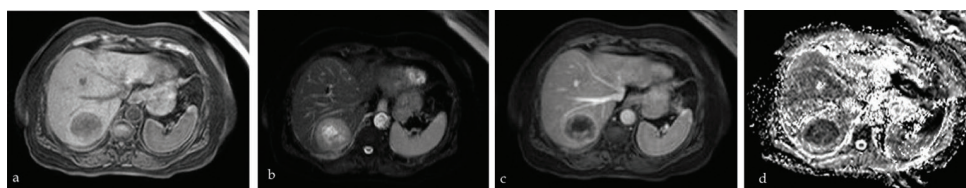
Hypovascular metastasis from colorectal cancer. a. Pre- and (c) post-contrast T1W image shows a hypointense mass with irregular peripheral enhancement. b. T2W magnetic resonance imaging shows heterogeneous high signal. d. Apparent diffusion coefficient map shows marked restriction of diffusion.
